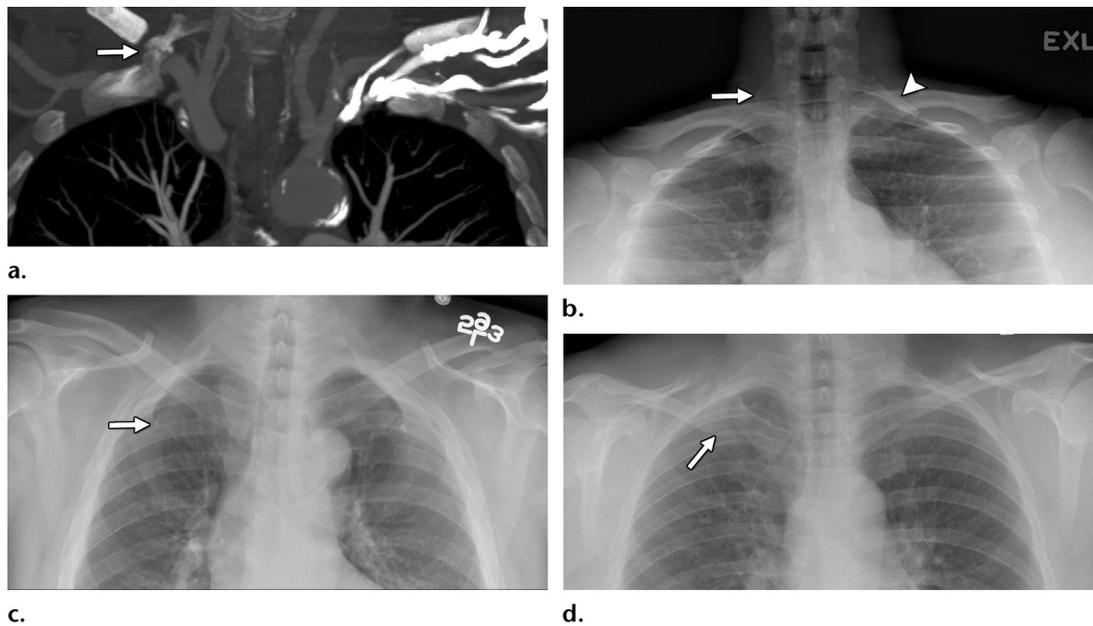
Bone abnormalities that can be associated with TOS. (a) Coronal maximum intensity projection (MIP) from CT shows a complete right cervical rib that forms an articulation with the right first rib (arrow). The patient was found to have incidental narrowing of the right subclavian artery due to the cervical rib on this pulmonary embolism protocol CT image, underscoring that not all patients with vascular narrowing at imaging have TOS. (b) Lordotic frontal chest radiograph shows an elongated C7 transverse process on the right (arrow) and an incomplete cervical rib on the left (arrowhead). (c) Frontal chest radiograph shows bilateral anomalous first ribs (arrow) that articulate with the second ribs. (d) Radiograph of a patient with a clinical diagnosis of neurogenic TOS shows an abnormal right clavicle (arrow) due to a bulky ununited fracture.
